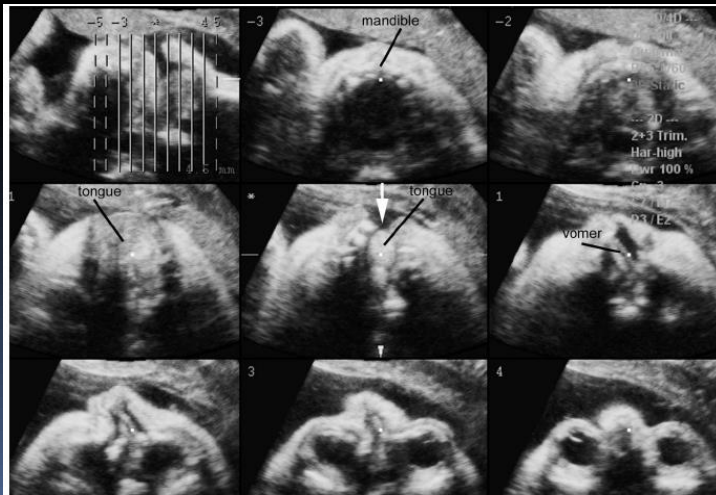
Tomographic ultrasound images in the axial plane of the fetus with cleft lip and palate. The defect of the alveolar ridge is well demonstrated (arrow), but the tongue obscures the edges of the defect. Note the deviation of the nose and of the vomer in the nasal fossae.
